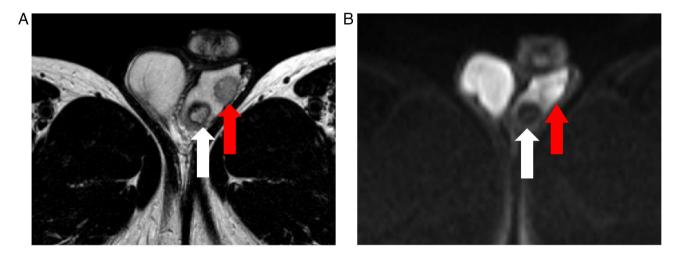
Preoperative magnetic resonance imaging of the left testis. (A) Magnetic resonance image of two tumors at T2 in the left testis. (B) Diffusion-weighted image shows hyperintensity in the cranial and hypointensity in the caudal part. The red and white arrows indicate the cranial tumor and caudal tumor, respectively.
